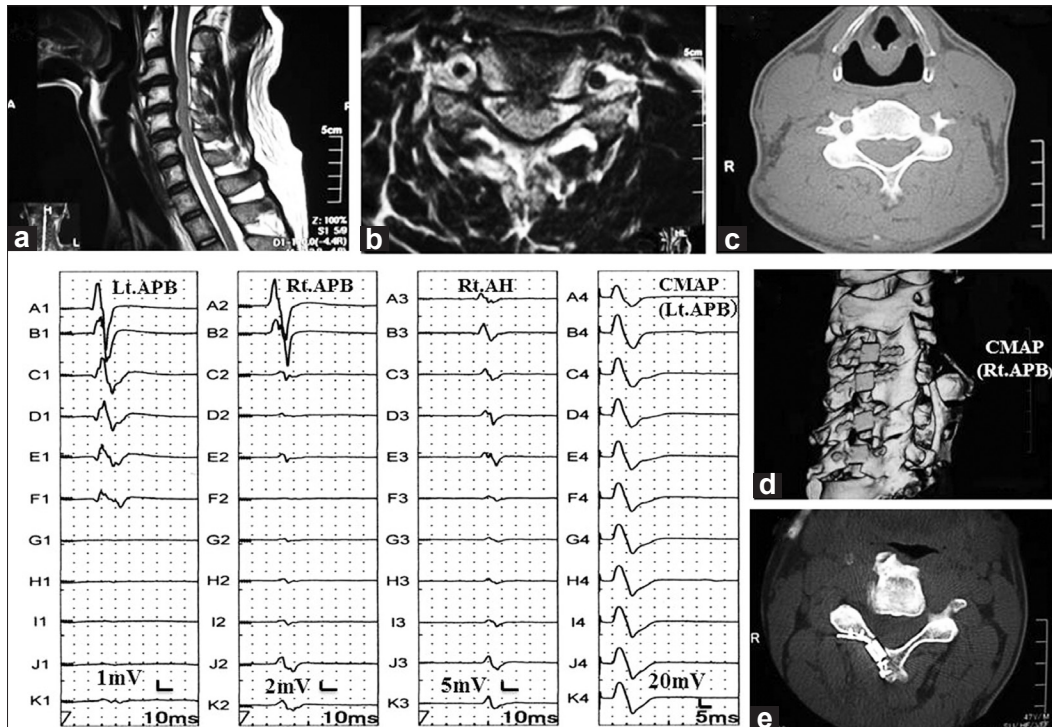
Case 2. A 47-year-old man had been struck by a motor vehicle while on his bicycle and suffered from motor weakness of his hands. The magnetic resonance image of his cervical spine showed marked spinal canal stenosis at C3-6 by spondylotic change (a-c). Right C3-6 unilateral open-door laminoplasty was performed a month after the trauma (d). Although full decompression was achieved (e), the amplitudes of transcranial motor-evoked potential decreased after decompression. The final amplitude reduction rates were 96% (left abductor pollicis brevis) and 89% (right abductor pollicis brevis) with compound muscle action potential compensation
